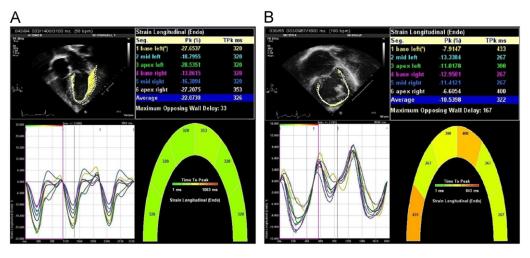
Example of strain curves derived by vector velocity imaging software displayed as time to peak strain among 6 cardiac segments in the apical 4chamber view (or equivalent) for a control subject (A) and a hypoplastic left heart syndrome subject (B). Variable times to peak strain are shown among the cardiac segments in the hypoplastic left heart syndrome subject compared with the control subject reflecting mechanical dyssynchrony.
